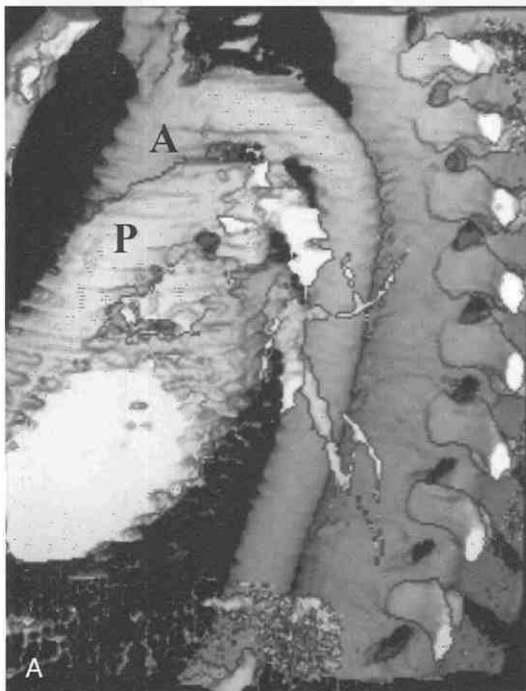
A, Sagittal oblique shaded surface display (SSD) shows the normal caliber of the thoracic aorta. Note the prominent cardiac pulsation artifacts in the aorta (A) and pulmonary artery (P). B, Sagittal oblique SSD of the normal thoracic aorta obtained with a multislice CT scanner. Note the absence of cardiac pulsation artifacts. Arrow denotes absence of pulsation artifacts in branch vessels.
